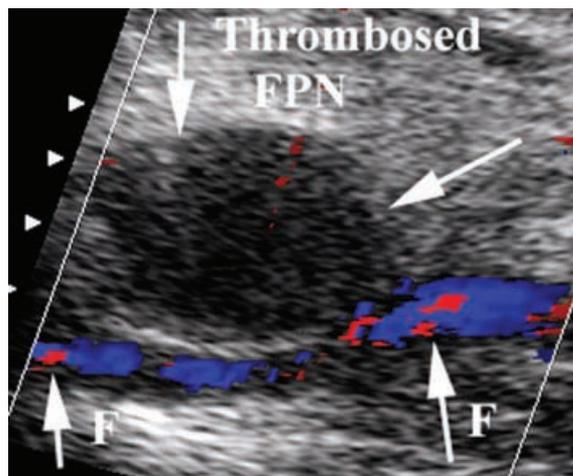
Ultrasound B-mode image and color Doppler of the right femoral artery (F) and the FPN after injection of 200 units thrombin. Rapid spontaneous thrombosis was visualized in real-time.
